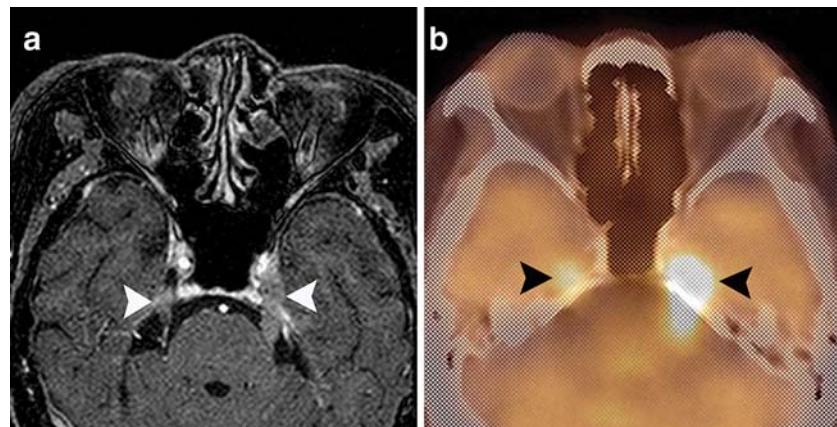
(a) Axial gadolinium-enhanced T1-weighted MRI showing enlargement and enhancement of the bilateral trigeminal nerves that was incorporating into the Meckel's caves, more prominent in the left side (white arrowheads). Note lack of diffuse leptomeningeal or brain parenchymal enhancement.
